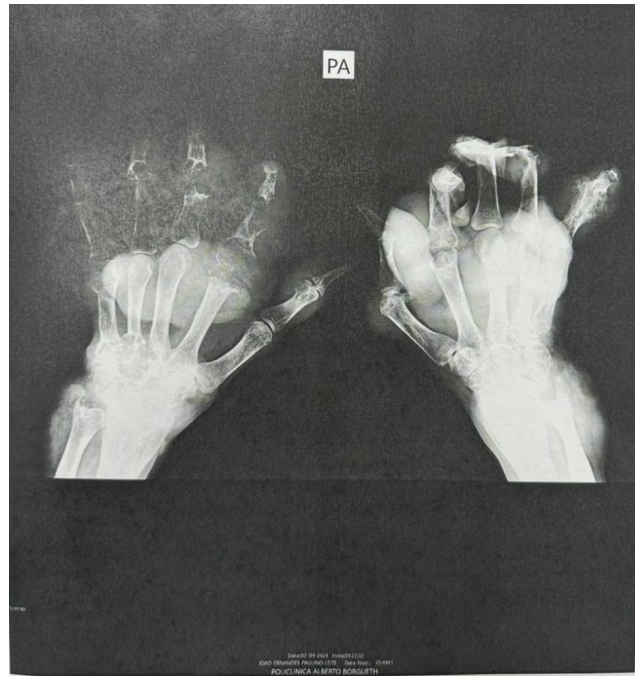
X-ray of both hands.
